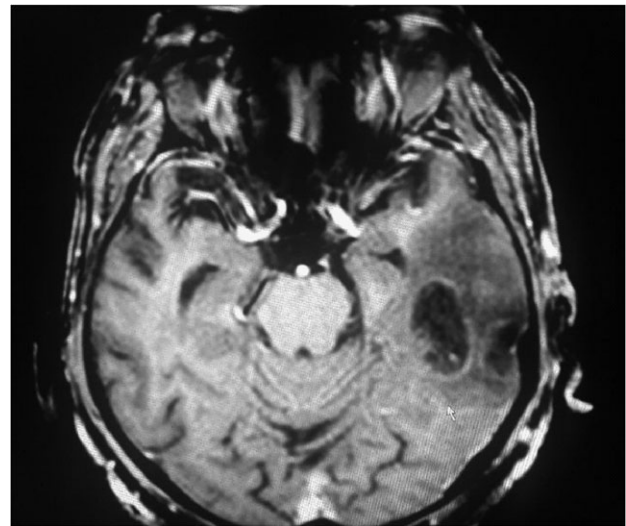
MRI at 5 days: T1 hypointense lesion increased upto the posterior limb of internal capsule with confluence and enlargement of hemorrhagic areas indicating interval increase in lesion.
